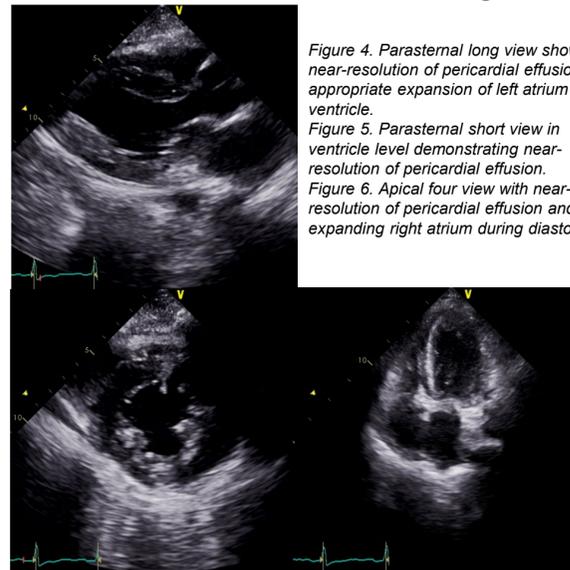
Parasternal long view showing near-resolution of pericardial effusion with appropriate expansion of left atrium and ventricle.
